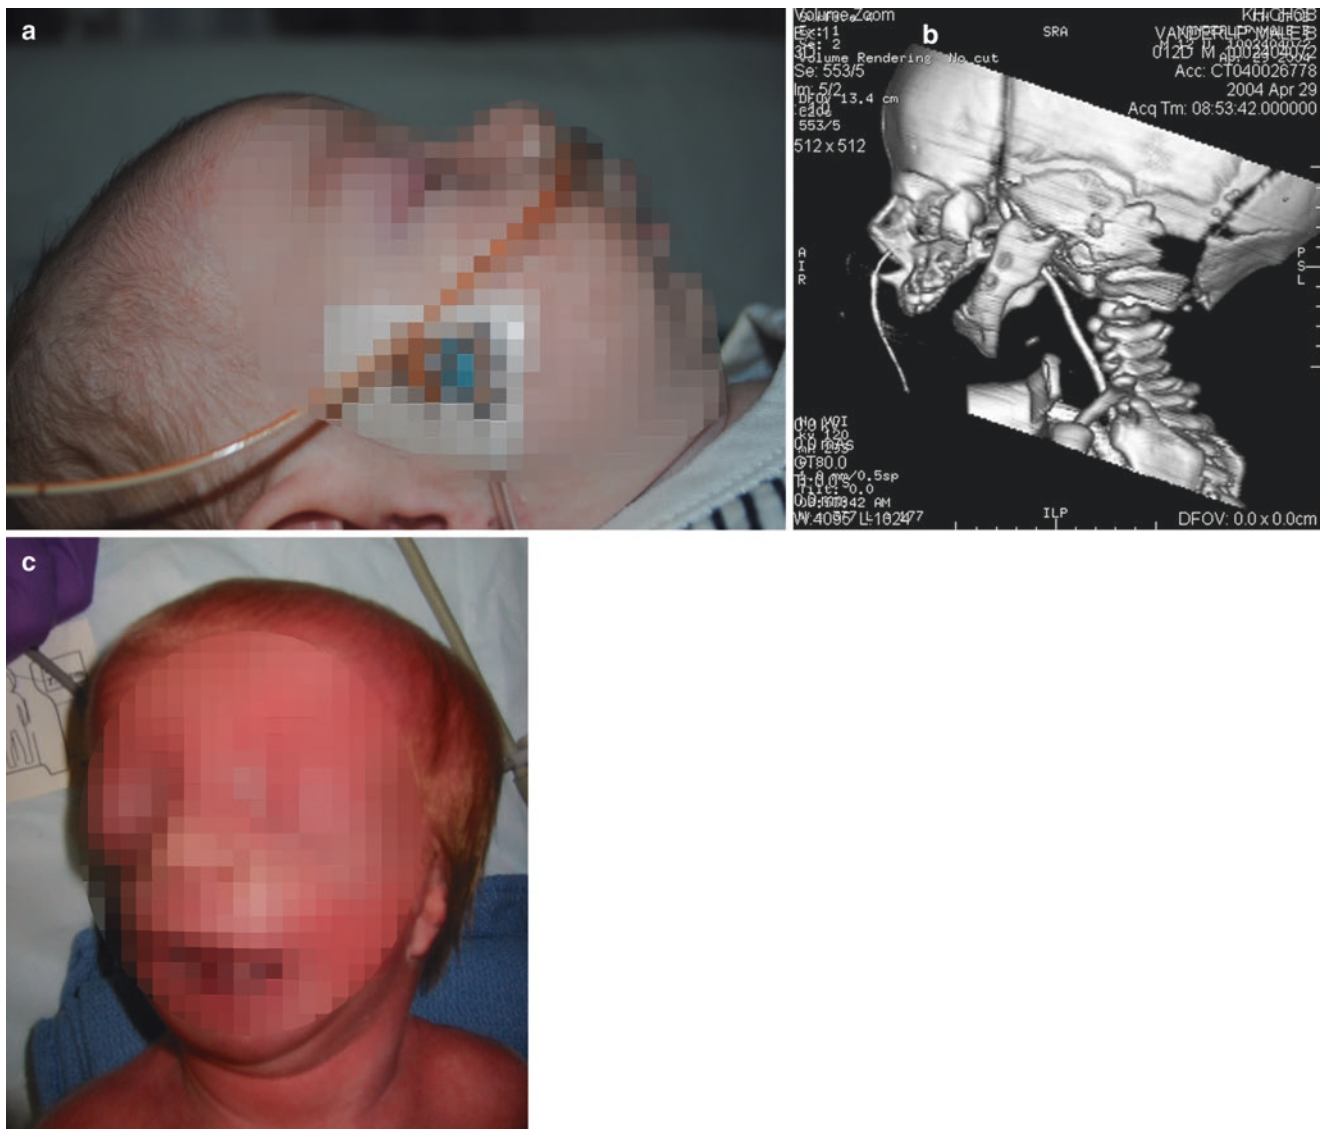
(a) Lateral profile of a 3-week-old male with Pierre Robin sequence. Note the retrognathic chin, which will impair laryngoscopy and tracheal intubation. (b) A three-dimensional CT reconstruction of a neonate with Pierre Robin sequence. Note the hypoplastic mandibular body length and severely obtuse gonial angle (see text). Courtesy of Dr.
